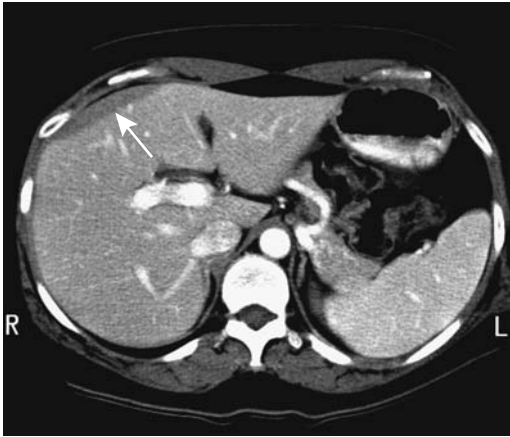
Radiation hepatitis after prior radiation therapy for breast carcinoma. CT outlines a focal, sharply defined anterolateral defect (arrow). (Courtesy of Patrick Fultz, M.D., University of Rochester.)
